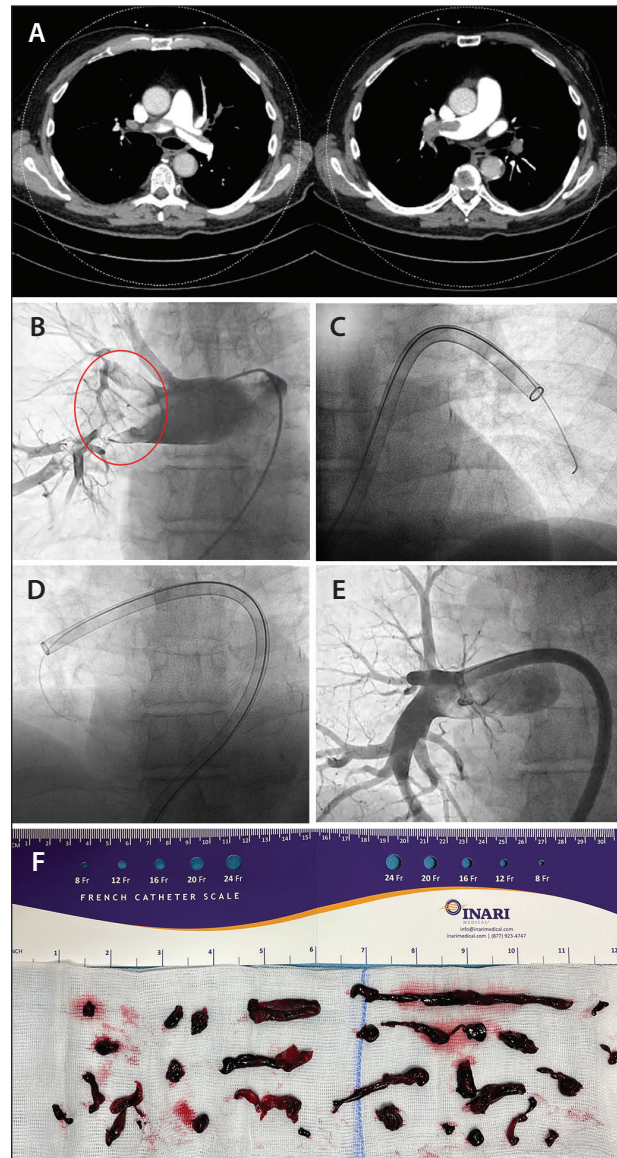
CT scan showed large central PE in the right and left pulmonary arteries (A). Phlebography confirmed the presence of large thrombus in the right pulmonary arteries (B). The large-bore FlowTrieve aspiration catheter was traversed through the right heart and placed adjacent to the thrombus on the left (C) and right (D) sides, with perfusion restored after aspiration thrombectomy (E). Extracted thrombus (F).
